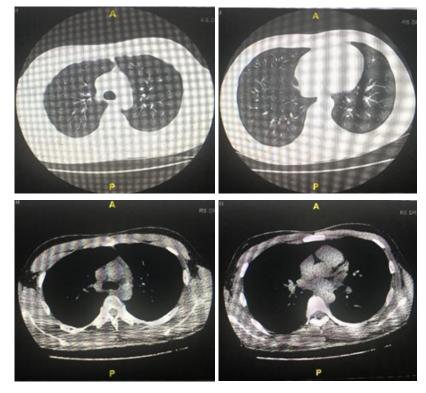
Chest CT of the patient.
